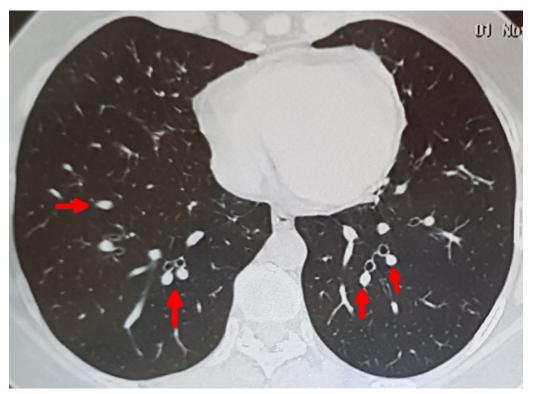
Multiple nodules in CT scan of the lungs
